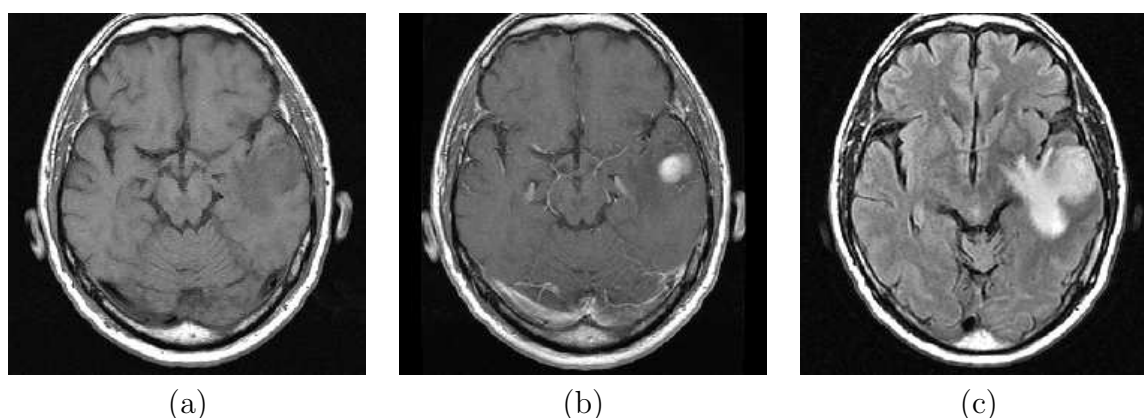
A full-enhanced tumor with edema. a) Axial slice of T1-weighted image. b) The same slice of contrast enhanced T1-weighted image. c) FLAIR image.
